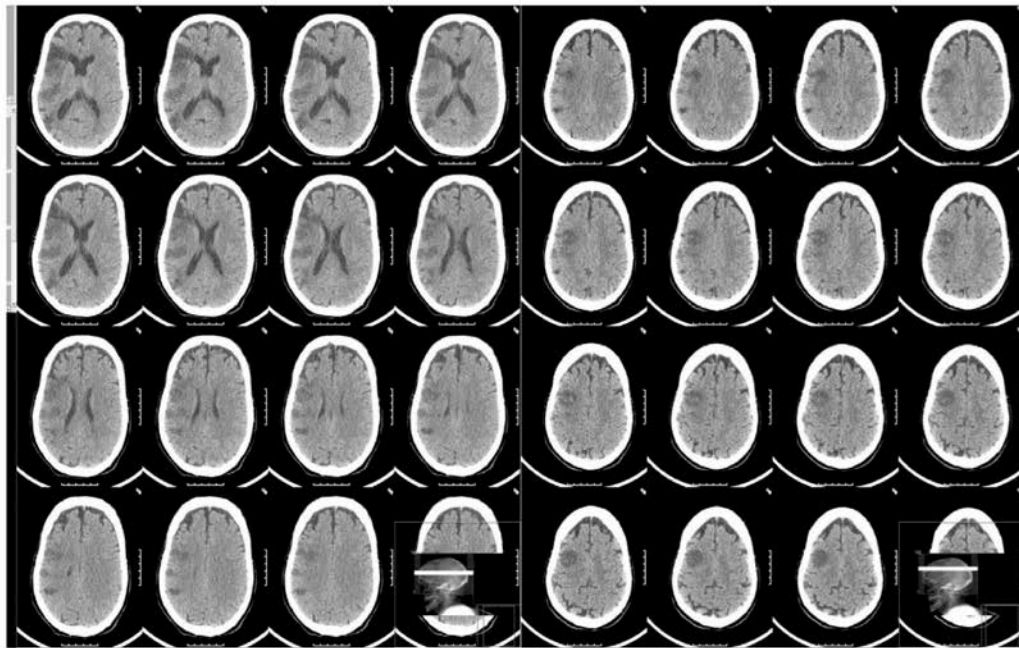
Plain head CT scan 24 h after thrombolysis disclosing an acute right MCA infarct, scoring 5 (1, M1, M2, M5, M6) on ASPECTS score, with spared cortical areas within the infarct zone.
